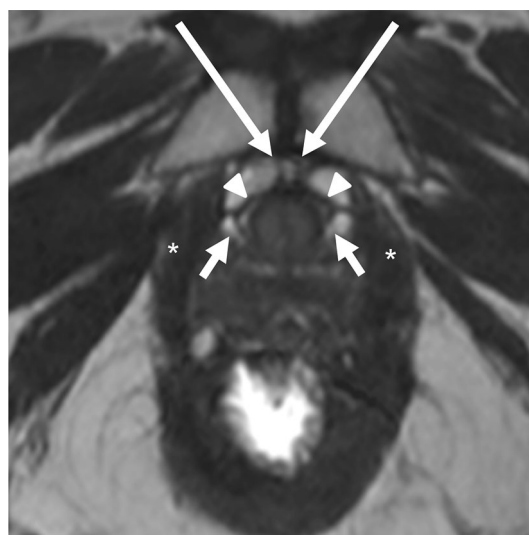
Urethral ligaments. Axial T2-weighted image demonstrates pubourethral ligaments (long arrows) coursing from the pubis to the anterior urethra. Periurethral ligaments (arrowheads) course from the urethral origin of the pubourethral ligaments to the medial aspects of the puborectalis muscle (*). Paraurethral ligaments (arrowheads) connect the lateral wall of the urethra to the periurethral ligaments
